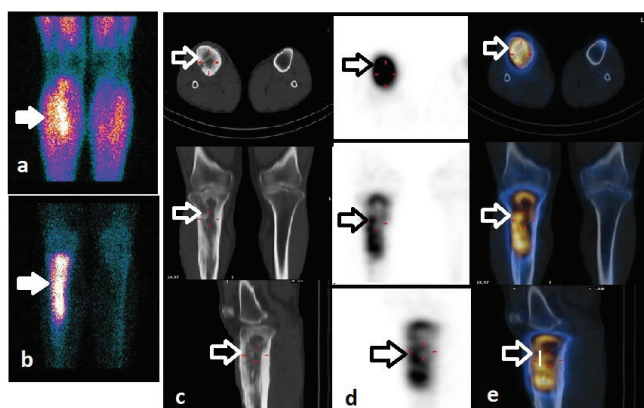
Three-phase planar bone scintigraphy of a 41-year-old man with right leg pain and erythema. (A) Blood pool (B) late static images show hyperemia and increased osteoblastic activity in right upper half tibia (arrows). (C) Axial, (D) coronal (E) sagittal computed tomography (CT), single photon emission computed tomography (SPECT) and SPECT/CT images. The heterogeneous increased uptake and chronic morphological changes are seen in the fusion images (arrows). The planar images suggest acute osteomyelitis without SPECT/CT. But chronic osteomyelitis is described with the morphological changes in the CT images. Chronic osteomyelitis is confirmed by pathology
